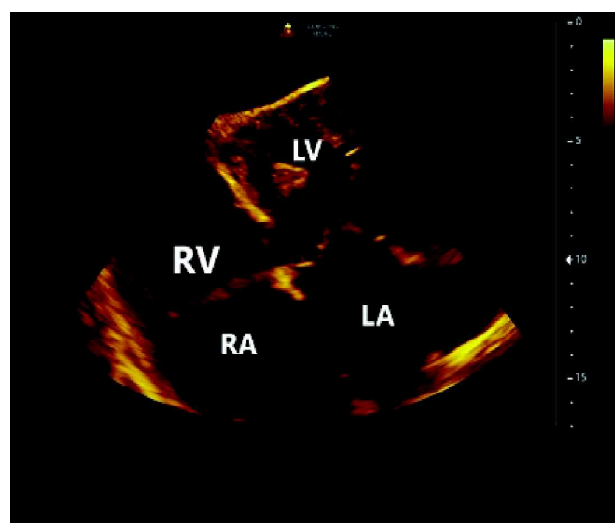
Echocardiography showing noncompacted LV and RV.
